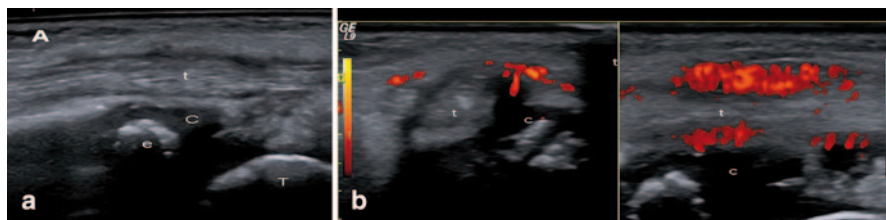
Tenosynovitis of the posterior tibialis tendon. a B-mode US image: Longitudinal US image shows tenosynovitis as the presence of anechoic synovial fluid surrounding the tendon and loss of the homogeneous fibrillar pattern of the tendon (*t*). *C*: cartilage of the distal end of tibia. *e*: secondary ossification center in tibial epiphysis. b Power Doppler US images: Longitudinal and transversal US images showing active inflammation
